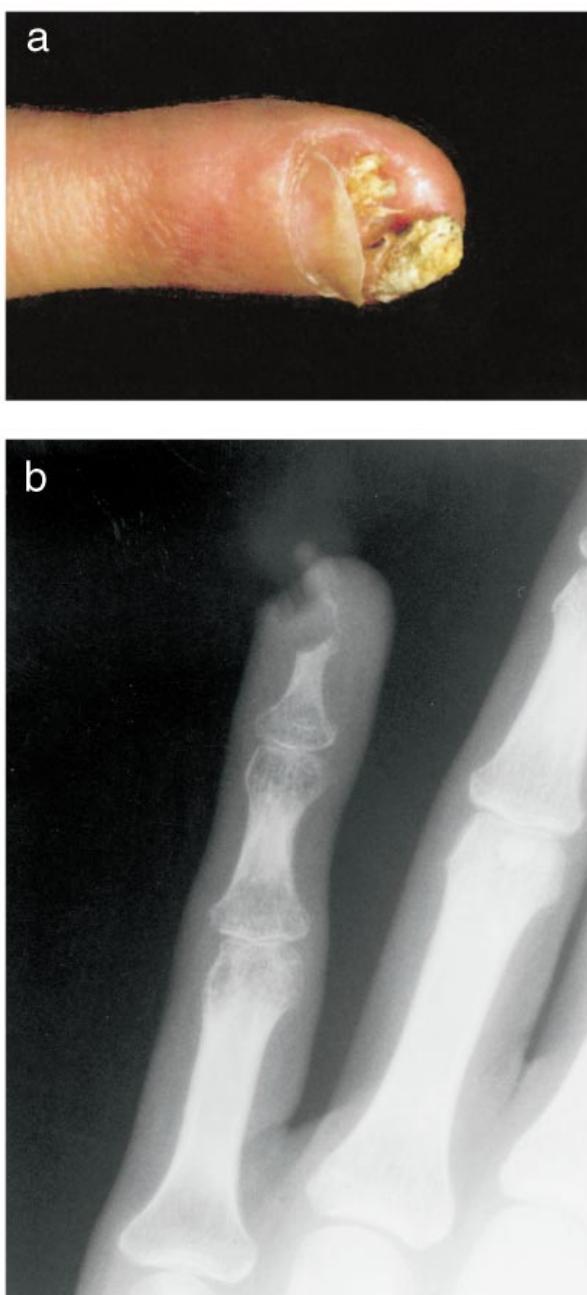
(a) The distal left little finger was swollen and erythematous, with a warty lesion raising up a shortened nail plate. (b) An X-ray suggested a malignant osteolytic tumour.
